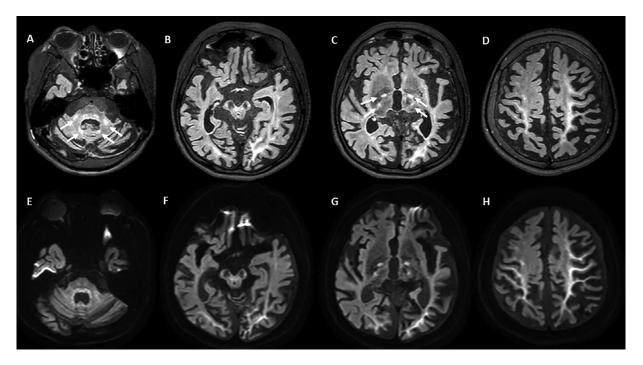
MRI at age 20 years shows severe atrophy of the brain, including the cerebrum, cerebellum, and brainstem. 3D FLAIR (TR/TE/TI, 6000/386/2000 msec, slice thickness, 1 mm) images (A-D) show signal hyperintensities in the middle cerebellar peduncles, paravermal regions (A: arrows), brainstem, globi pallidi, thalami, internal capsules (C: arrows), and subcortical white matter involving U-fibers. DWI ($b = 1000 \text{ s/mm}^2$, TR/TE, 6273/84 msec, slice thickness, 3mm without gap) shows hyperintensities in these lesions with restricted diffusion (E-H).
